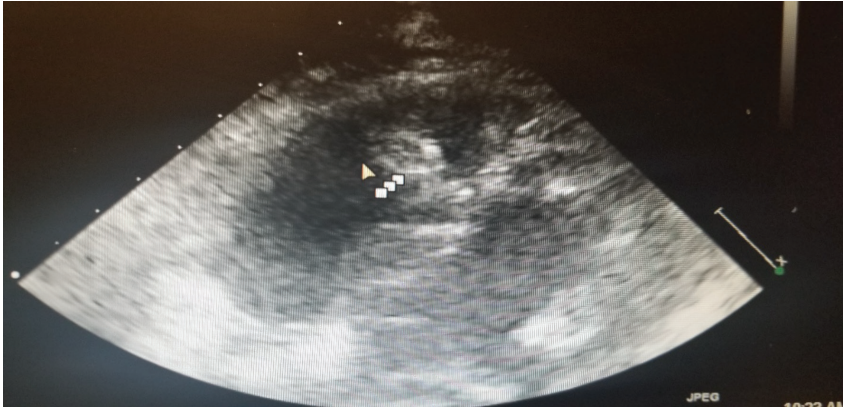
Mass well seated over the moderator band on apical 4-chamber view.
